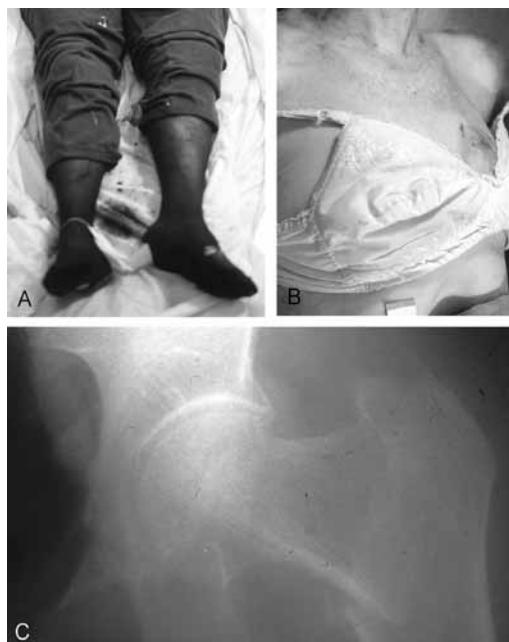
Elderly woman found dead on patio in winter. Hypothermia (see [Fig. 9](#)). (A) Shortened and externally rotated left leg. (B) “Paradoxical” undressing. (C) Postmortem radiograph-fractured left femur, which incapacitated victim.
